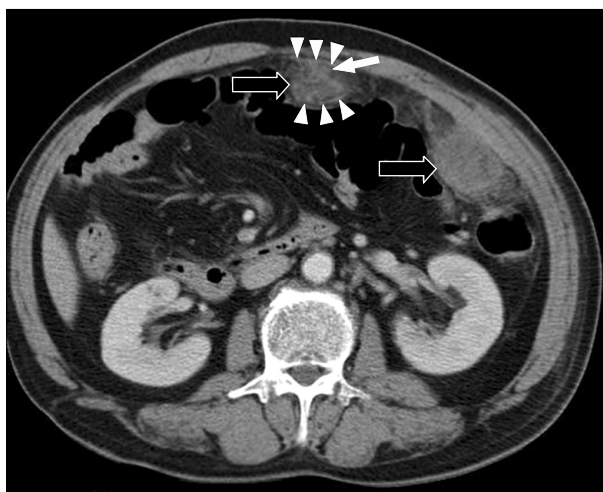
Contrast-enhanced abdominal computed tomography (CT) showing two heterogeneous mixed low- and high-attenuation masses (open arrows) in the omentum around the transverse colon. The fat-ring sign (arrow), which is the omental fat surrounding the omental vessels, is noted. A tumoral pseudocapsule (arrowheads) is also evident as anterior and posterior thin hyperdense rims surrounding the omental mass.
